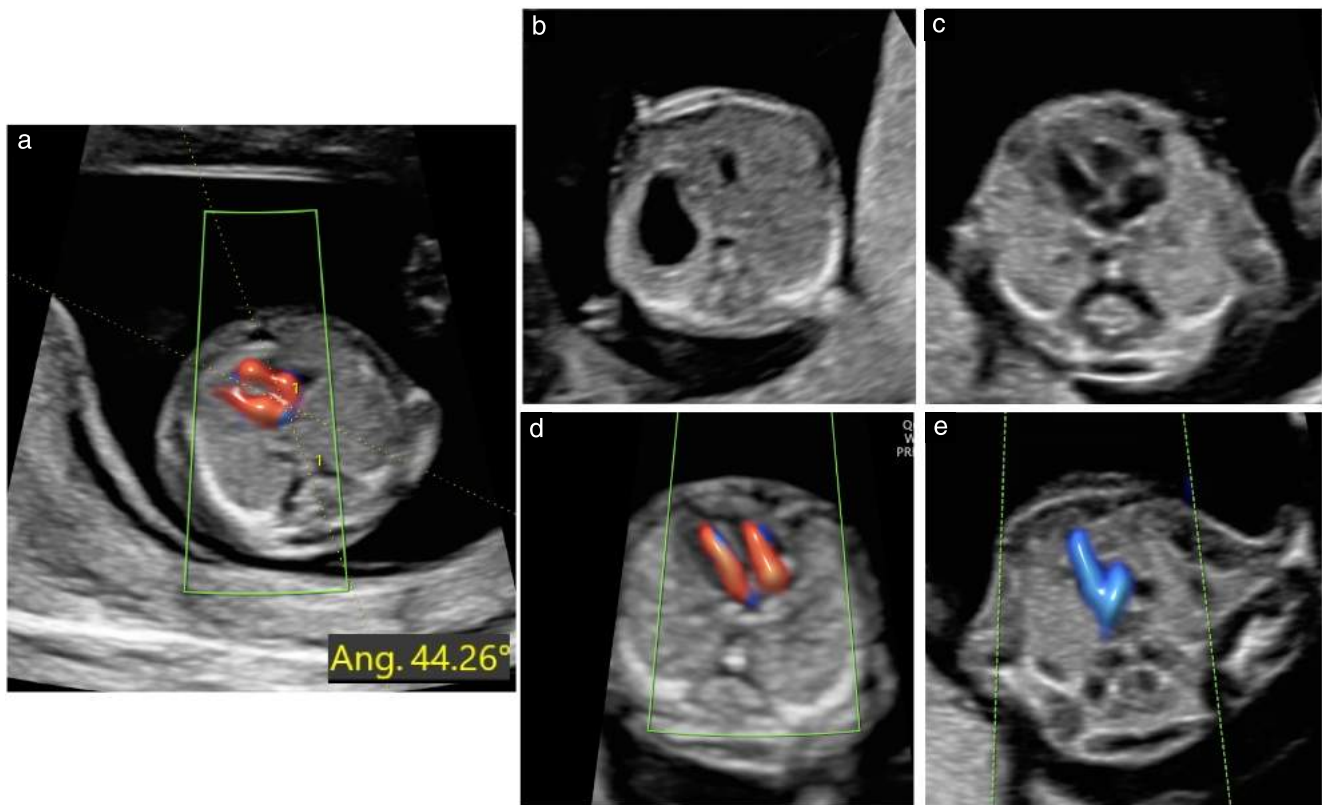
Cardiac examination in early gestation should focus on these selected planes, similar to second-trimester examination: (a) demonstration of cardiac axis (calipers), (b) abdominal view with demonstration of stomach on left side, (c) four-chamber view (grayscale), (d) four-chamber view (color Doppler) during diastole and (e) three-vessel-and-trachea view (color Doppler) during systole.
